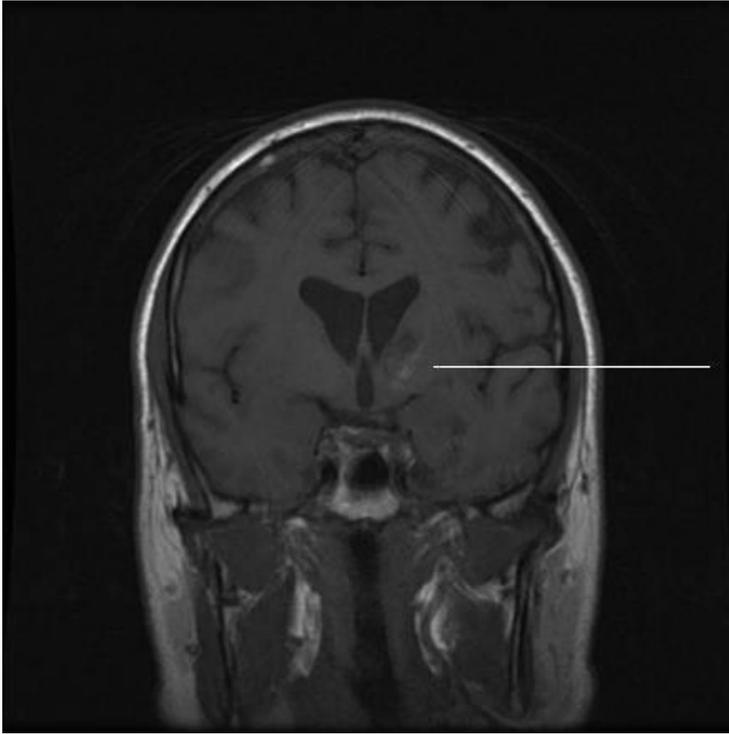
Primary CNS vasculitis. T₁-weighted MRI of the brain showed left basal ganglia hemorrhage. Reproduced with permission from [10].
